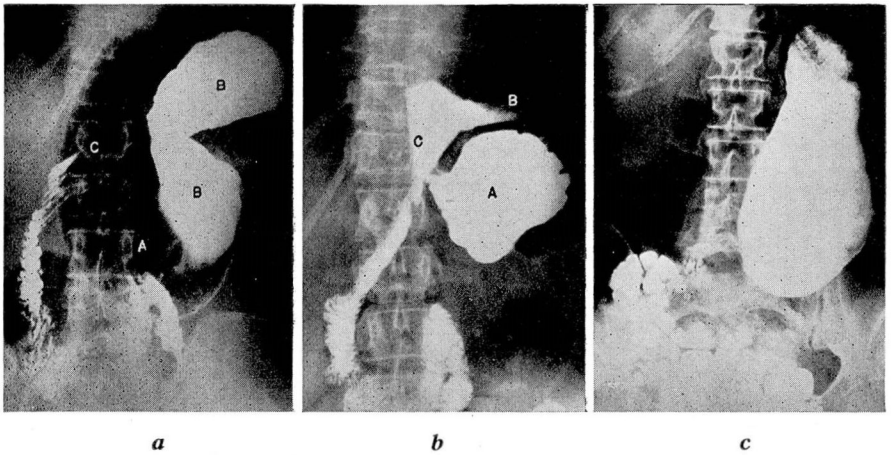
Case 1. Roentgenograms demonstrating
